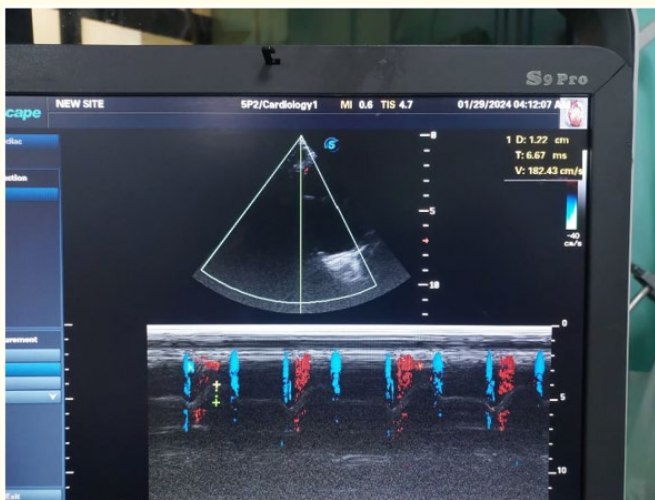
2D-echocardiography 4 chamber view, M-MODE, shows decrease TAPSI.
